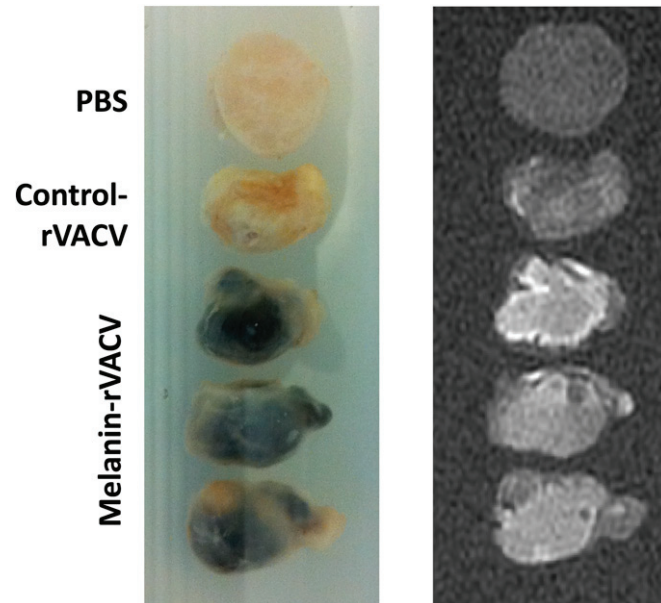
Melanin-dependent signal enhancement in a clinical 3-T MRI scanner. Isolated A549 tumors were embedded in agarose (*Left*) and scanned at 3 T (*Right*). Melanin-containing regions appear bright on the T1-weighted images, whereas no melanin-containing tumors (or tumor regions) appear darker on the same images.
